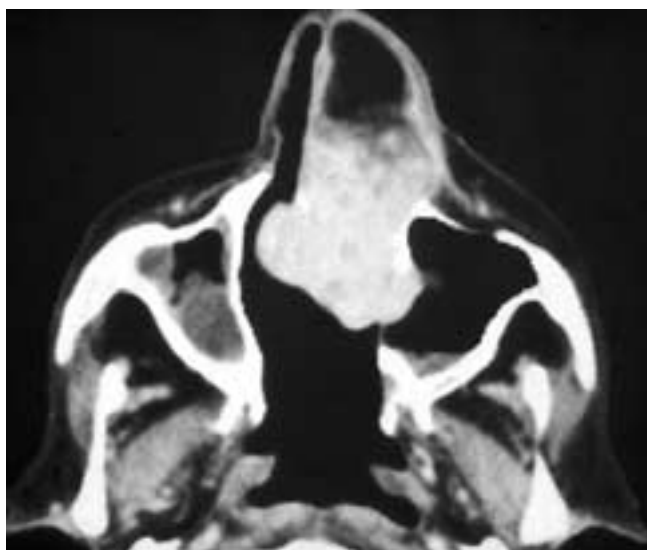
Axial CT scan shows a bulky nodular mass arising in the nasal septum and laterally displacing the left nose and medial antral wall. This patient had a pleomorphic adenoma.
